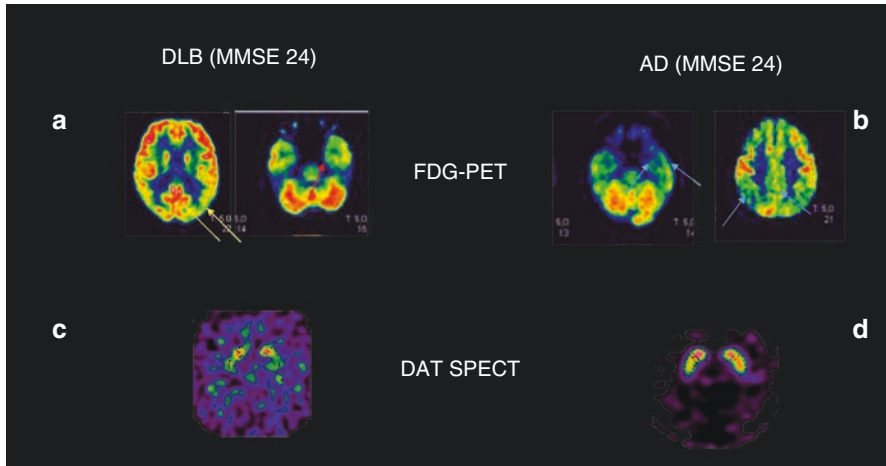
Molecular imaging findings in dementia with Lewy bodies (DLB) versus Alzheimer's disease (AD). Panel a: with respect to AD, DLB patients are characterized by hypometabolism in lateral occipital cortex as well as in precuneus with relatively spared metabolism in posterior cingulate (yellow arrows) and in medial temporal lobe (red arrow). Panel b shows the temporoparietal hypometabolic pattern (with marked posterior cingulate hypometabolism) in an AD patient expressing the same level of cognitive impairment. It has to be noted that DAT SPECT is to date the most appropriate tool to support the clinical differential diagnosis between DLB (Panel c: markedly reduced uptake) and AD (Panel d: normal scan)
